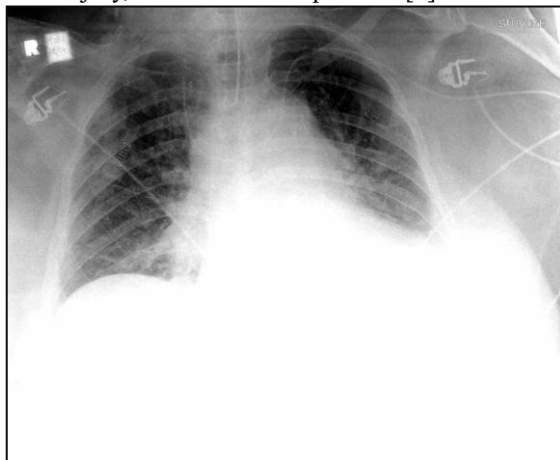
Malpositioned Central Line, Chest Radiograph.
